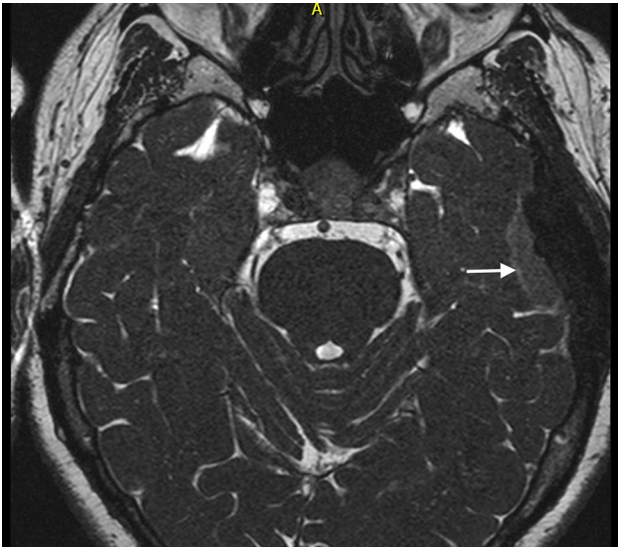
Magnetic resonance imaging, axial native T2-weighted scan, CISS sequence. A typical band of cerebrospinal fluid between the intra-axial space (brain tissue) and the extra-axial tumor originating from the meninges is evident (white arrow)
